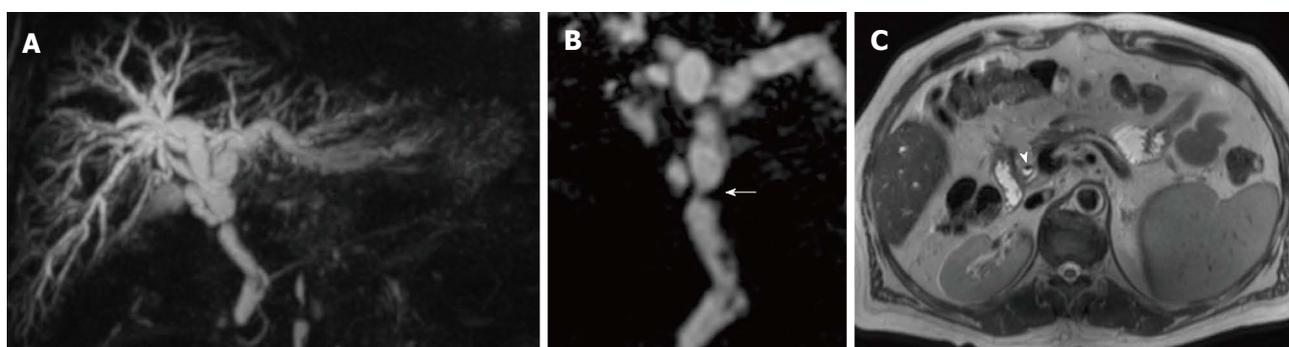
Anastomotic stricture in a 54-year-old male patient who underwent orthotopic liver transplantation for alcoholic cirrhosis. A: Coronal MIP reconstruction shows the stricture at the middle third of the extrahepatic bile duct, with biliary dilatation upstream; B: The degree of the stricture is better delineated on the paracoronally-reformatted thin 3D image (arrow); C: Filling defects visible on MRC images correspond to pneumobilia, appearing as air-fluid levels (arrowhead) on the axial T2-weighted HASTE sequence. MRC: Magnetic resonance cholangiography; MIP: Maximum intensity projection.
